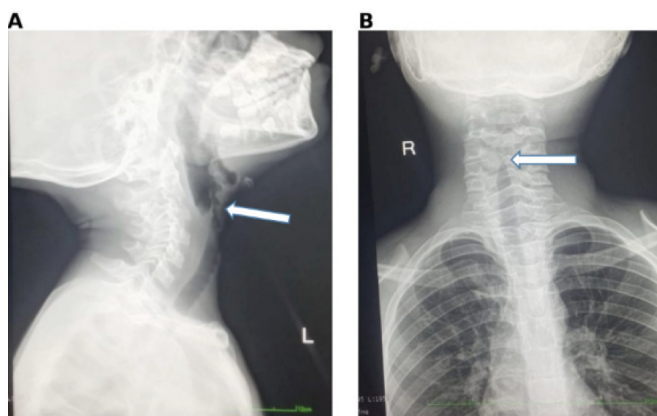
Soft tissue neck radiographs of the patient demonstrating laryngeal airway narrowing. (A) Lateral view showing irregular soft tissue opacities within the laryngeal region with narrowing of the upper airway column. (B) AP view showing relative narrowing of the upper airway at the laryngeal level.
